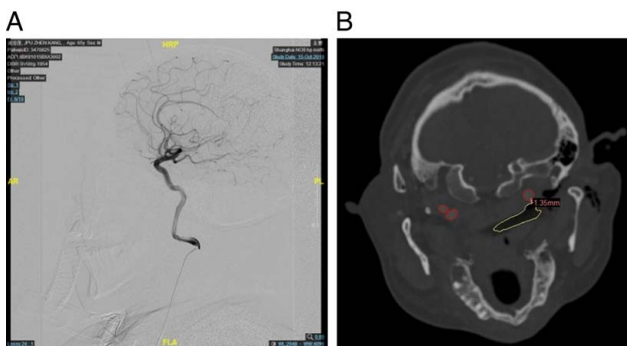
Digital subtraction angiography (A) and CT (B) showed no obvious defects in the arteries of the neck, and the closest distance to the carotid artery was 1.35 mm (yellow indicates the foreign body, and red indicates the carotid artery). CT indicates computed tomography.
